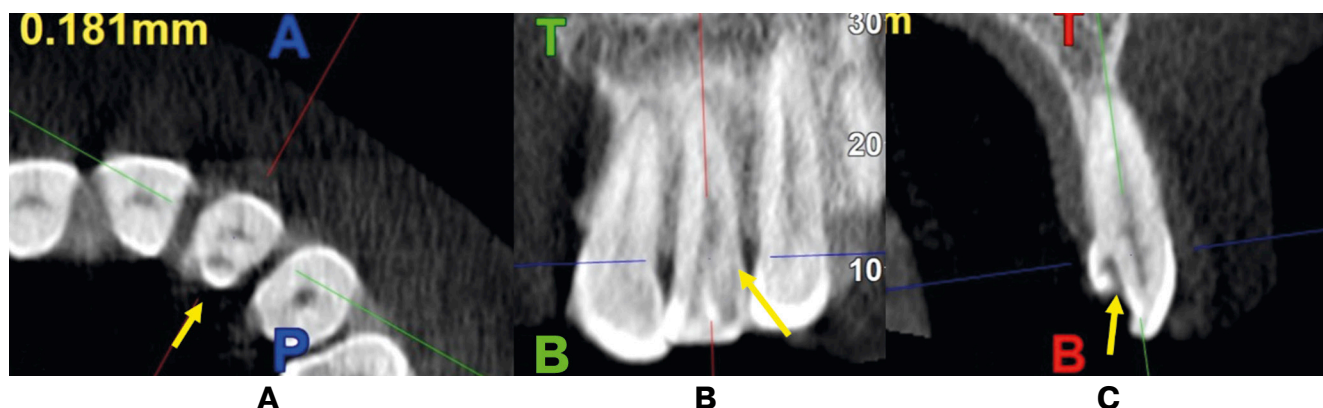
Cone beam computed tomography images showing Oehler's Type I dens invaginatus with palatogingival groove in left maxillary lateral incisor in (A) axial, (B) coronal and (C) sagittal sections
